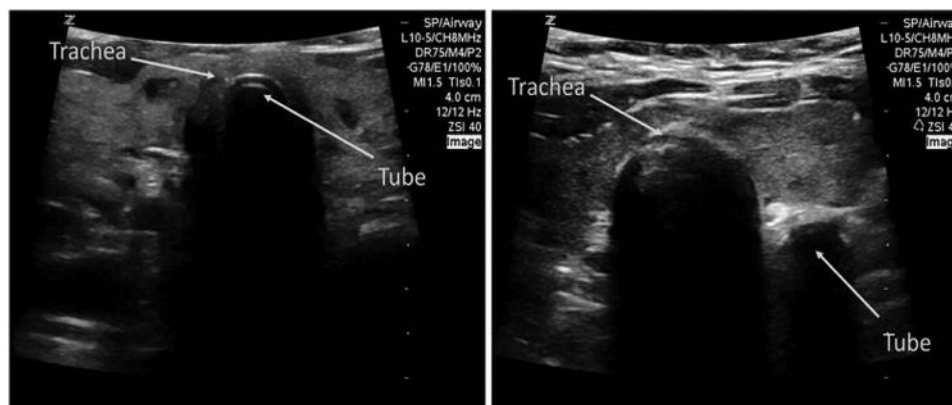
Ultrasound image of an airway using a linear probe to confirm proper placement of an endotracheal tube. The left panel shows the tracheal wall, and the rim of the endotracheal tube is the hyperechoic line just posterior to the tracheal wall. On the right, the wall of the trachea is shown, and another air-filled structure is next to it (note the shadowing), which is an endotracheal tube in the oesophagus; this is referred to as the “double-tract” sign (figure courtesy of Elaina Lin).
